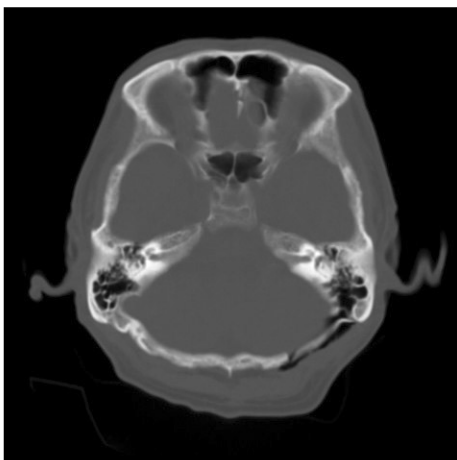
Axial computed tomography scan performed at 2 months after surgery shows the epidural pneumatocele and subgaleal air collection in the left posterior fossa communicating freely with the air cell system of the mastoid cavity, without fluid collection. Bone wax is pushed into the mastoid air cell.
